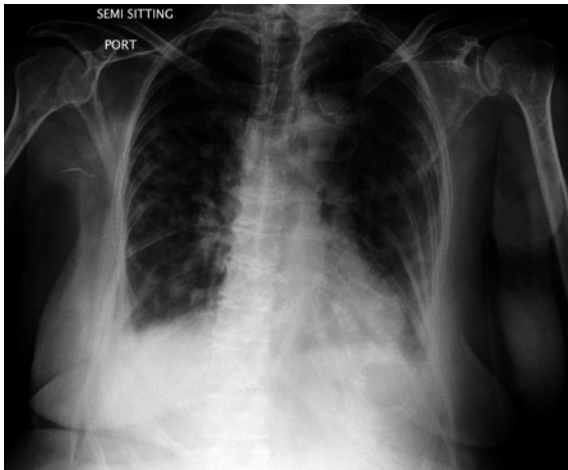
Chest radiograph taken during the acute onset of dyspnoea shows bilateral pulmonary infiltrates.
